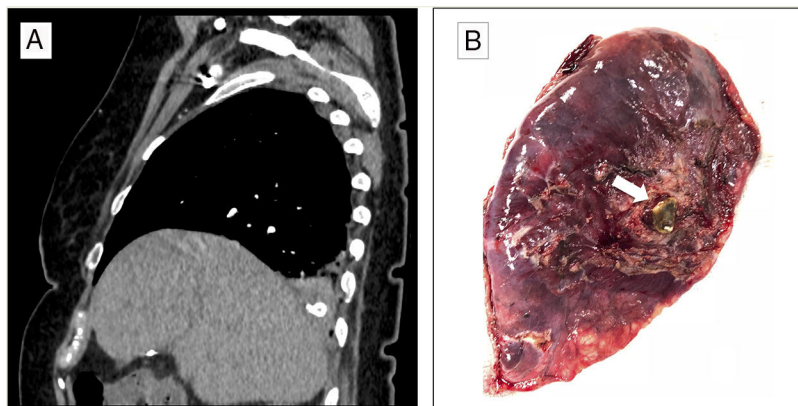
(A) Sagittal image of the CT scan that shows foreign body with calcium density located in the right lower lung. (B) Image of the pulmonary resection showing the gallstone (arrow).
